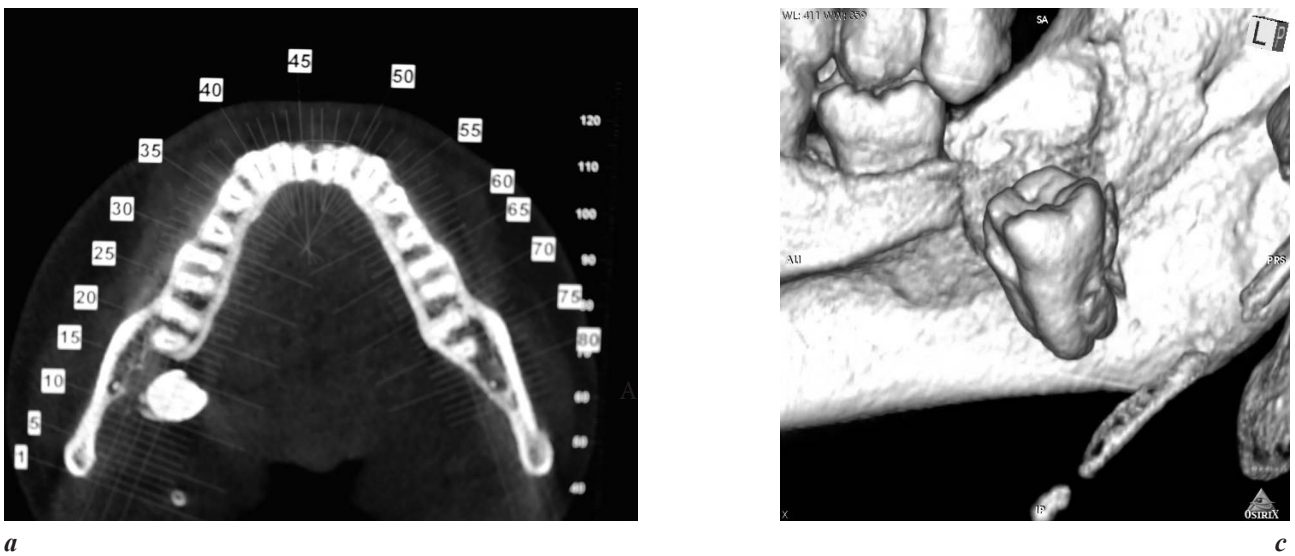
CBCT axial section (a), cross sections (b) and 3D reconstruction (c).
